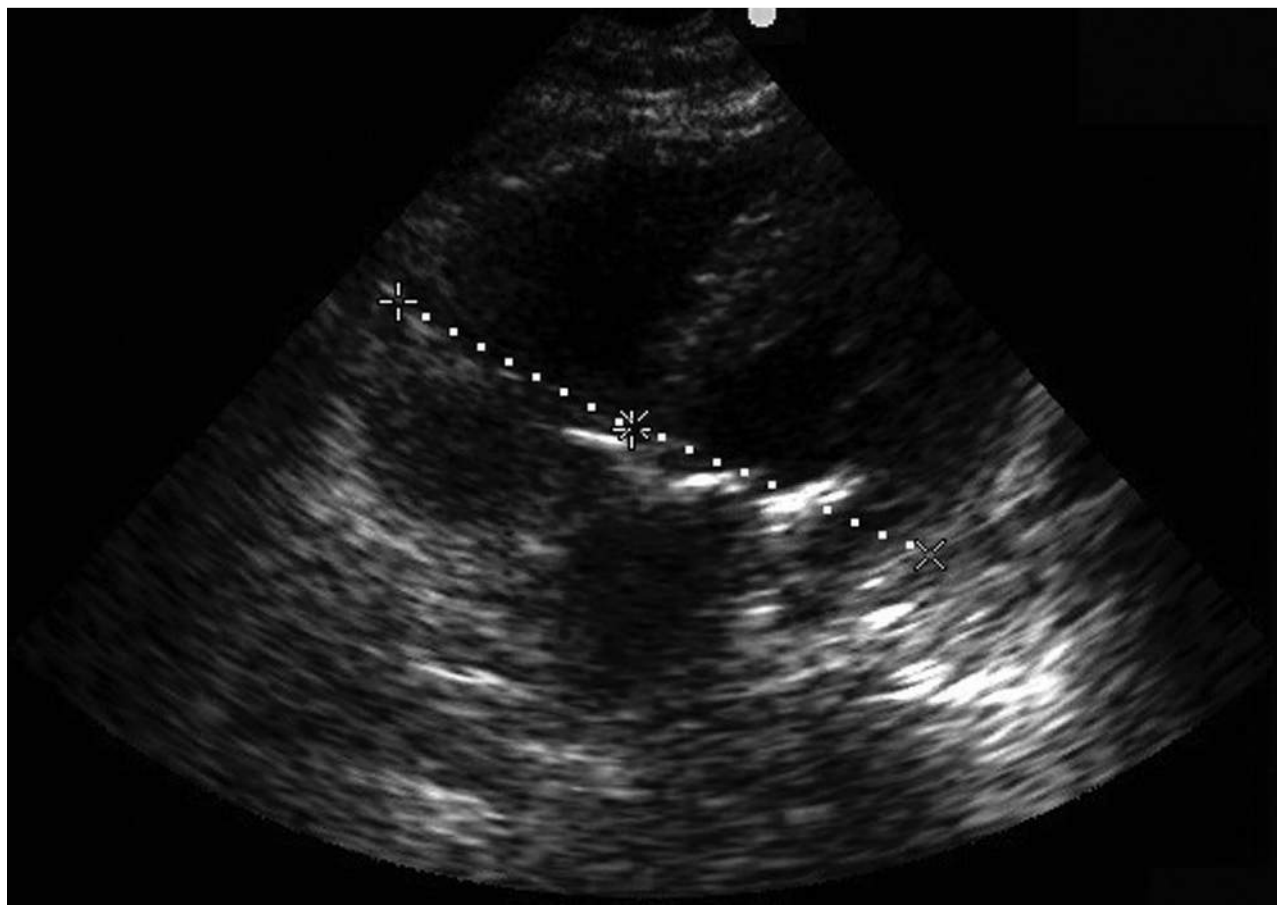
Apical four-chamber view showing right ventricular dilation. Note the right ventricle and left ventricle are almost equal in size at end diastole.
